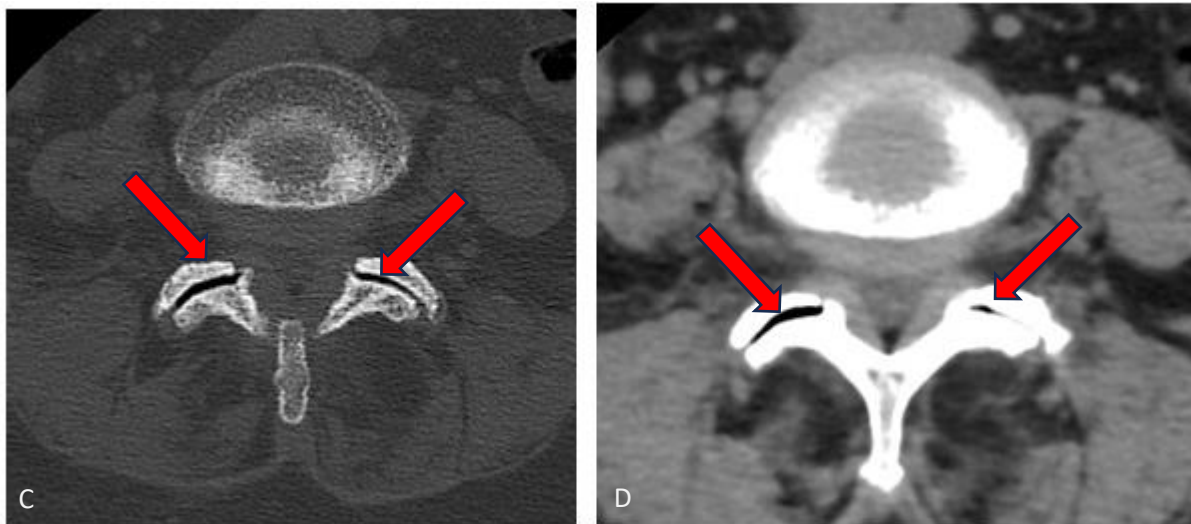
A-B: *A): spondylolisthesis L4-L5; B): facet joint hypertrophy and sclerosis; C): axial CT with the bone algorithm: vacuolar degeneration of the facet joint; D): axial CT with soft tissue algorithm: ligamentum flavum hypertrophy.*
